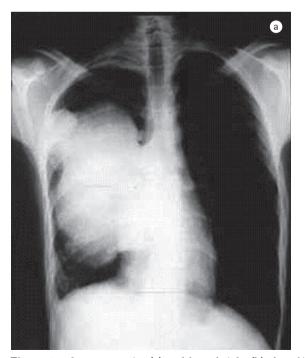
Anteroposterior (a) and lateral right (b) chest X-ray showing the large right pulmonary mass, with clear hilar involvement.
